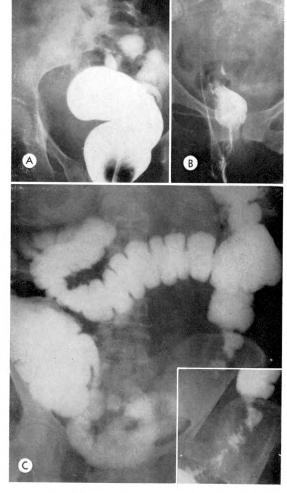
Case No. A4156. Seventy year old white female with chief complaints of crampy pain in the right lower abdominal quadrant and localized tenderness over the course of the lower descending and pelvic colon. (A and B) Complete blockage of the barium is noted in mid-sigmoid (pre and post evacuation roentgenograms). (C and Insert) Hypaque enema 40 per cent delineates the entire colon and demonstrates the area of narrowing and irregularity, which is due to diverticulitis. Note the excellent filling of the colon, well defined haustral markings, diverticula at various levels of the colon, and the incompletely filled diverticula at the lower descending and sigmoid colon.
